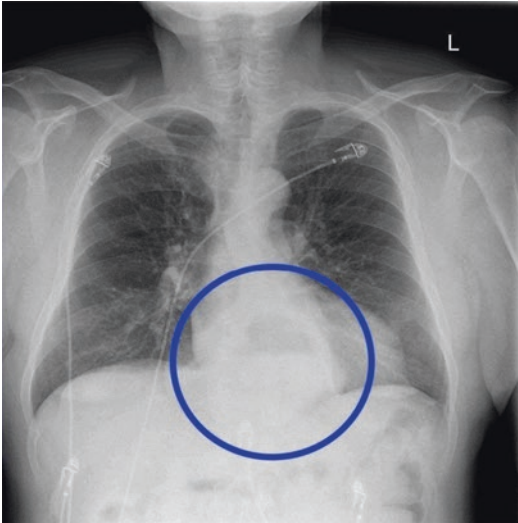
Diaphragmatic hernia with fluid level projected over the mediastinum. Note this is a hiatus (non-traumatic) hernia, but diaphragmatic rupture can present with a similar fluid level or bowel contents visible in the chest on x-ray (Ahmed Farhat and Daryn Towle via Wikimedia [Under CC-BY 4.0 license])
